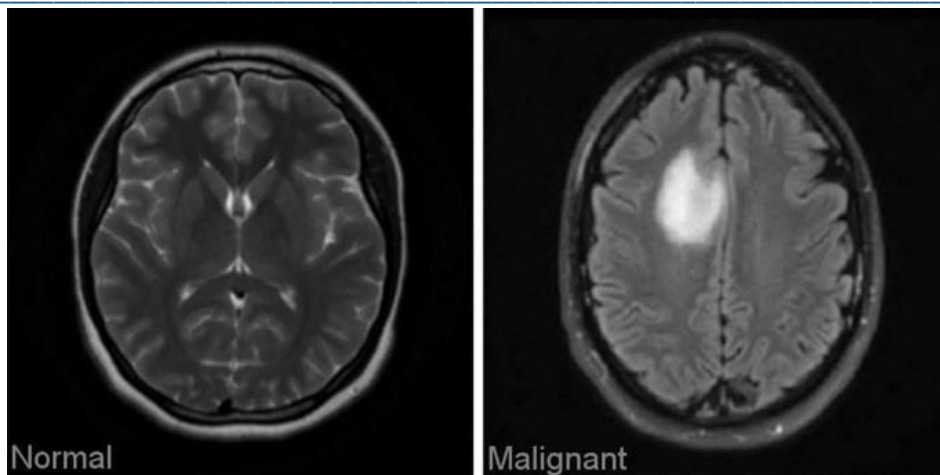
MRI Brain Images Showing Normal and Malignant Tumor Conditions
